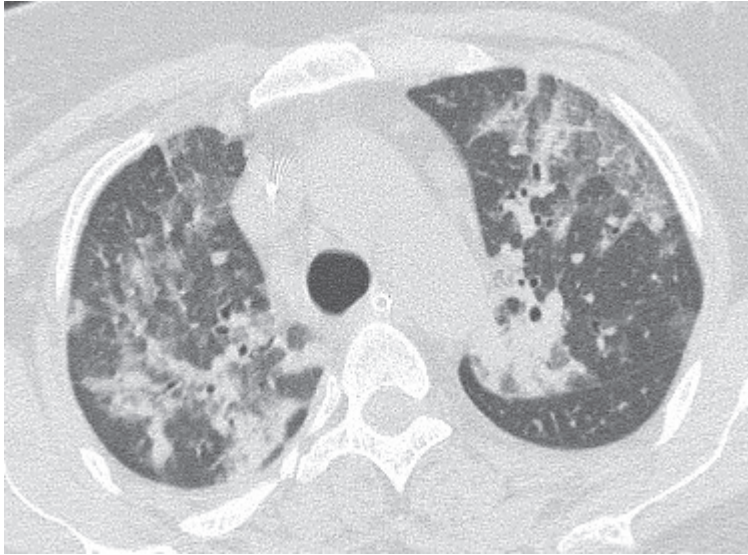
A chest CT scan finding of the same patient with bronchopneumonia revealed more wide spread opacities.
